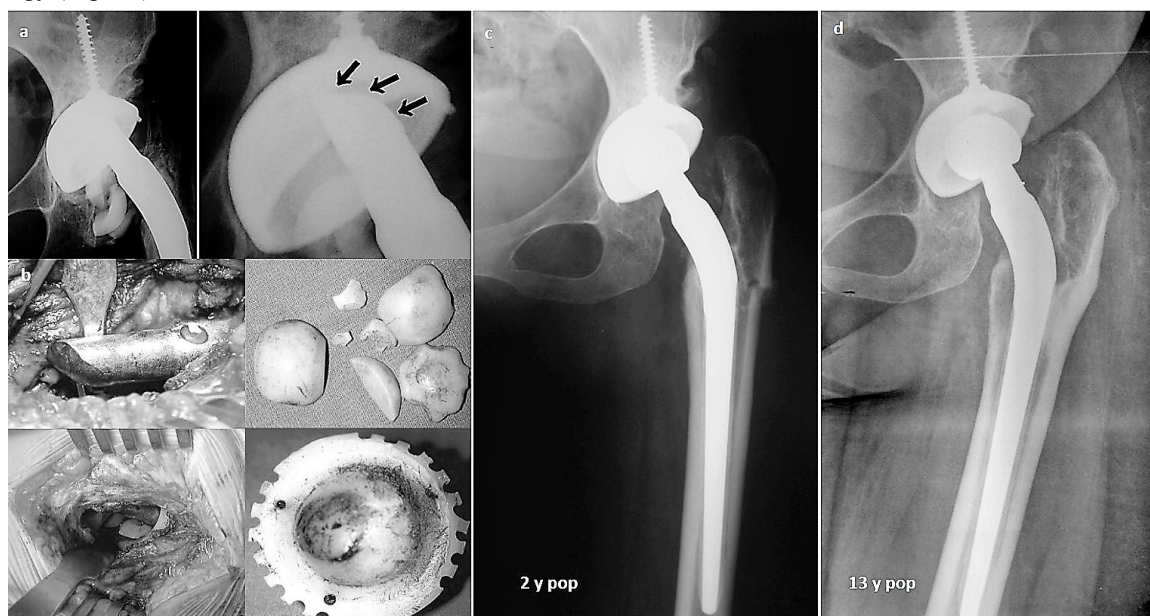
(a). Plain hip x-ray demonstrated multifragment ceramic head failure associated with severe notching of the cone (arrows), (b). intraoperative findings at revision operation showing diffuse metallosis, multifragmented ceramic head, notching of the cone and severe polyethylene insert wear, (c). follow up x-ray at 2 years and (d). final x-ray 13 years after revision operation.
